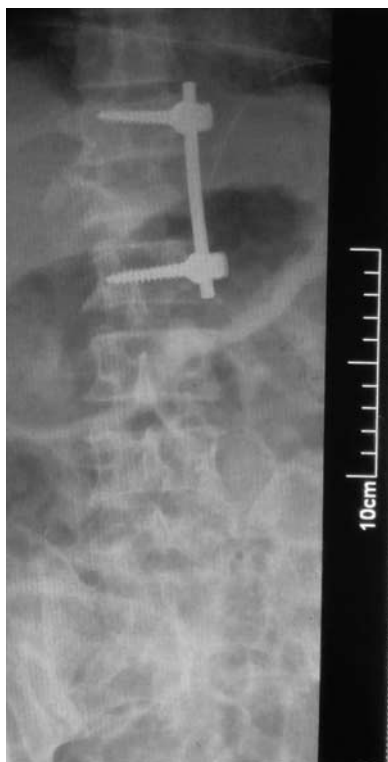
Postoperative x-ray in the anteroposterior view.
